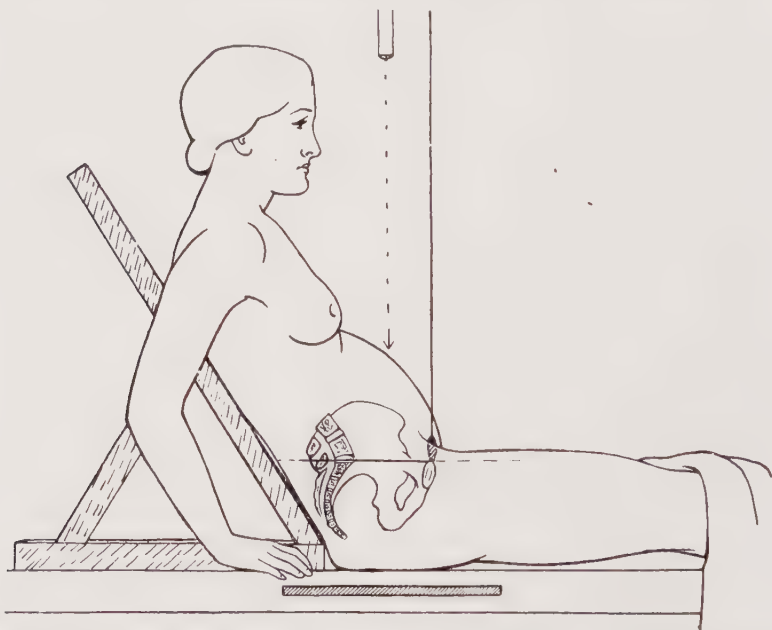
RADIOLOGICAL PELVIMETRY. TO SHOW POSITION OF THE PATIENT, FILM, X-RAY TUBE, AND PLUMB-LINE.
